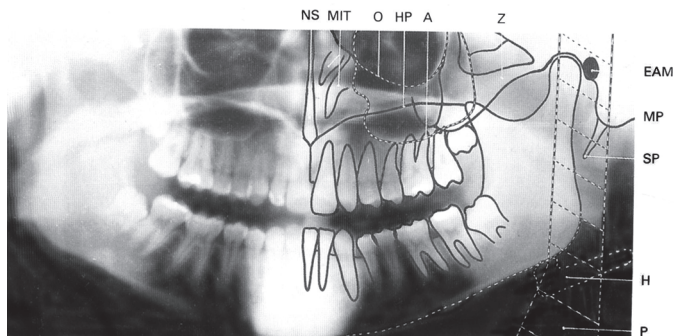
A panoramic radiograph showing shadows. NS - nasal spine, MIT- middle and inferior turbinates, O-orbital margin, HP- hard palate, A-floor of maxillary sinus, Z-zygomatic arch, EAM - external auditory meatus, MP-mastoid process, SP-styloid process, H-hyoid bone, P-plastic head support
